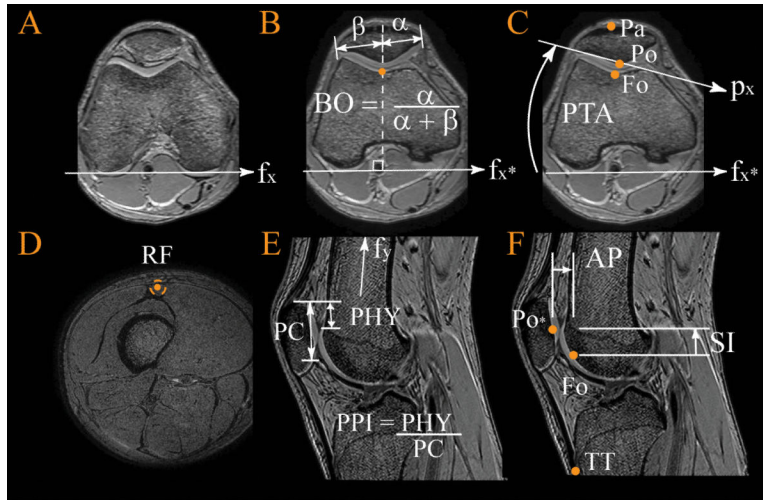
Static Magnetic Resonance Imaging-based Measures of Patellofemoral Alignment
